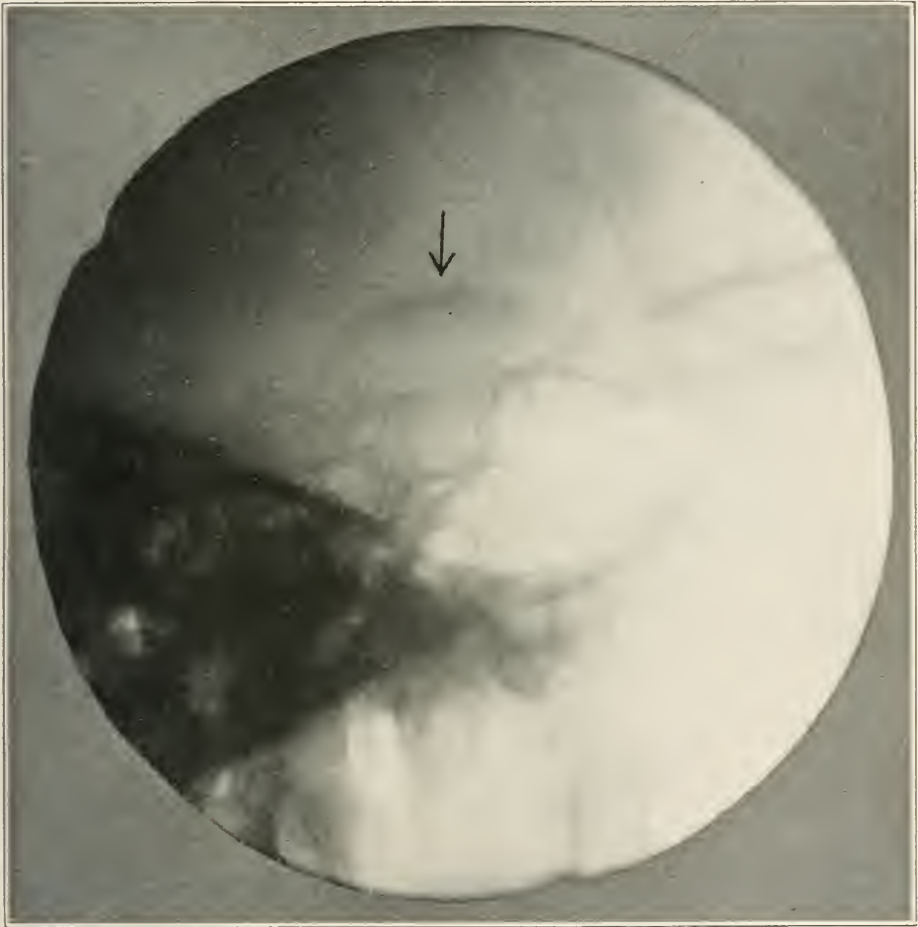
Crescentic shadow above the sella turcica, shown by the roentgenogram in Case 1.
